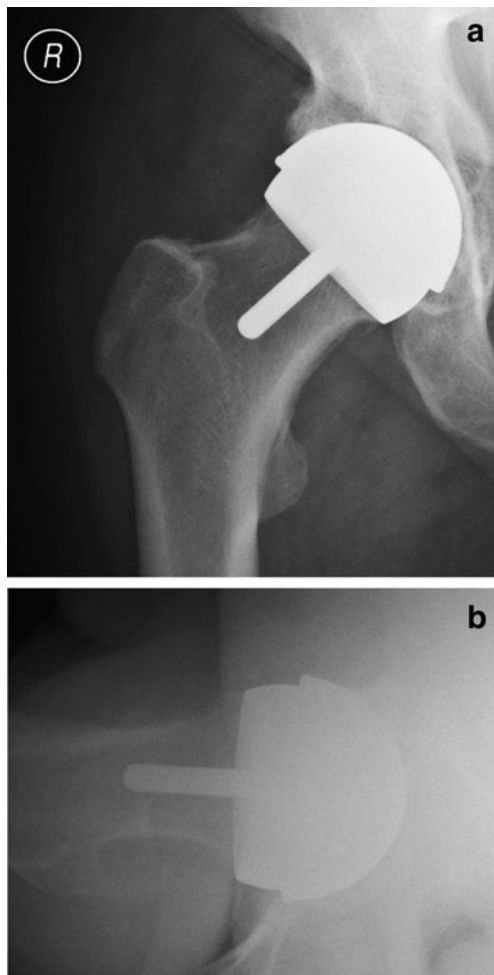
a frontal and b lateral radiograph of RSA showing optimum position of the components
